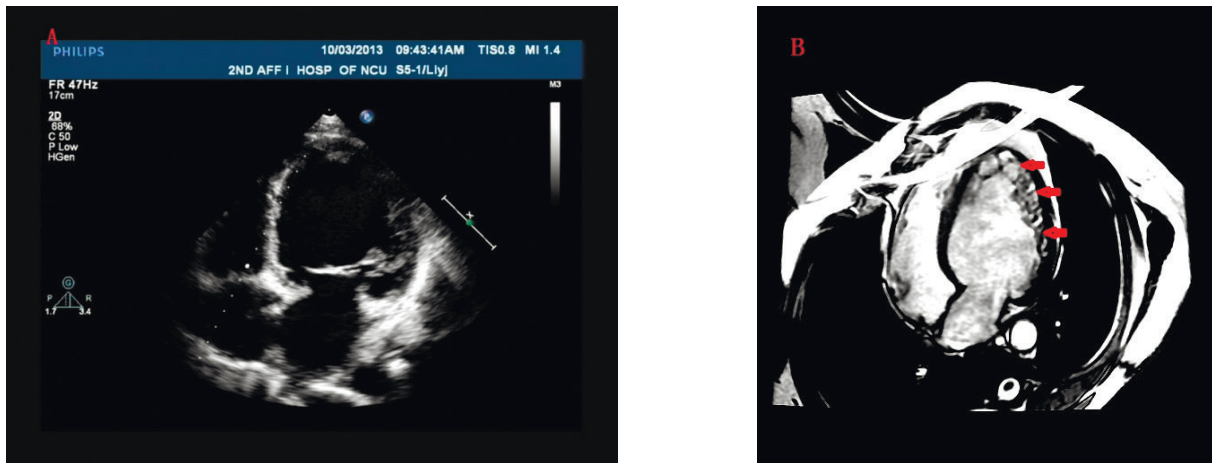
The apical 4-chamber plane, which was detected by echocardiography showed the enlargement of left ventricle, and the thickening of lateral wall was considered to be caused by DCM (A). But CMR showed trabeculation and deep intertrabecular recesses (B), LGE didn't find any abnormal enhancement within the myocardium, and made the diagnosis of NCC.
